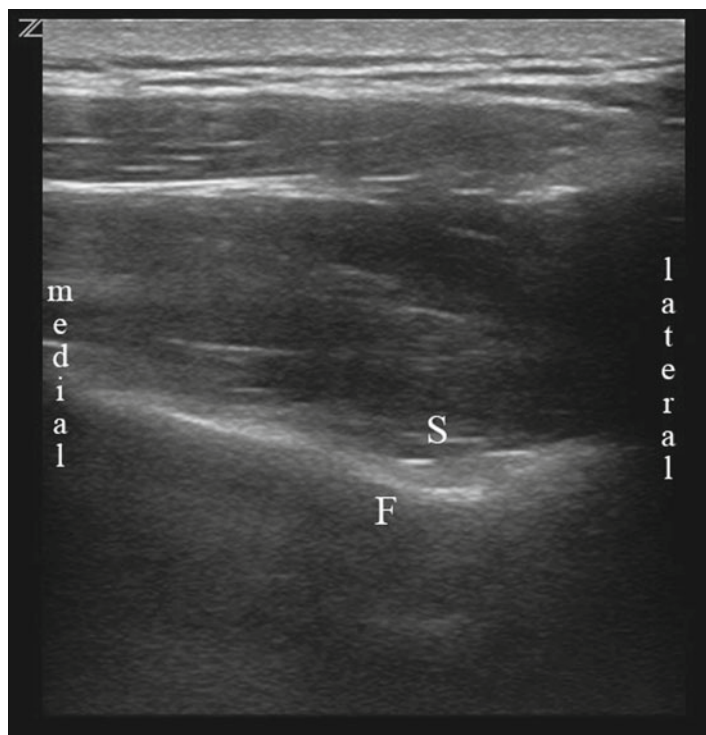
Ultrasonographic appearance of the suprascapular fossa (*F* fossa, *S* supraspinatus muscular fascia)
